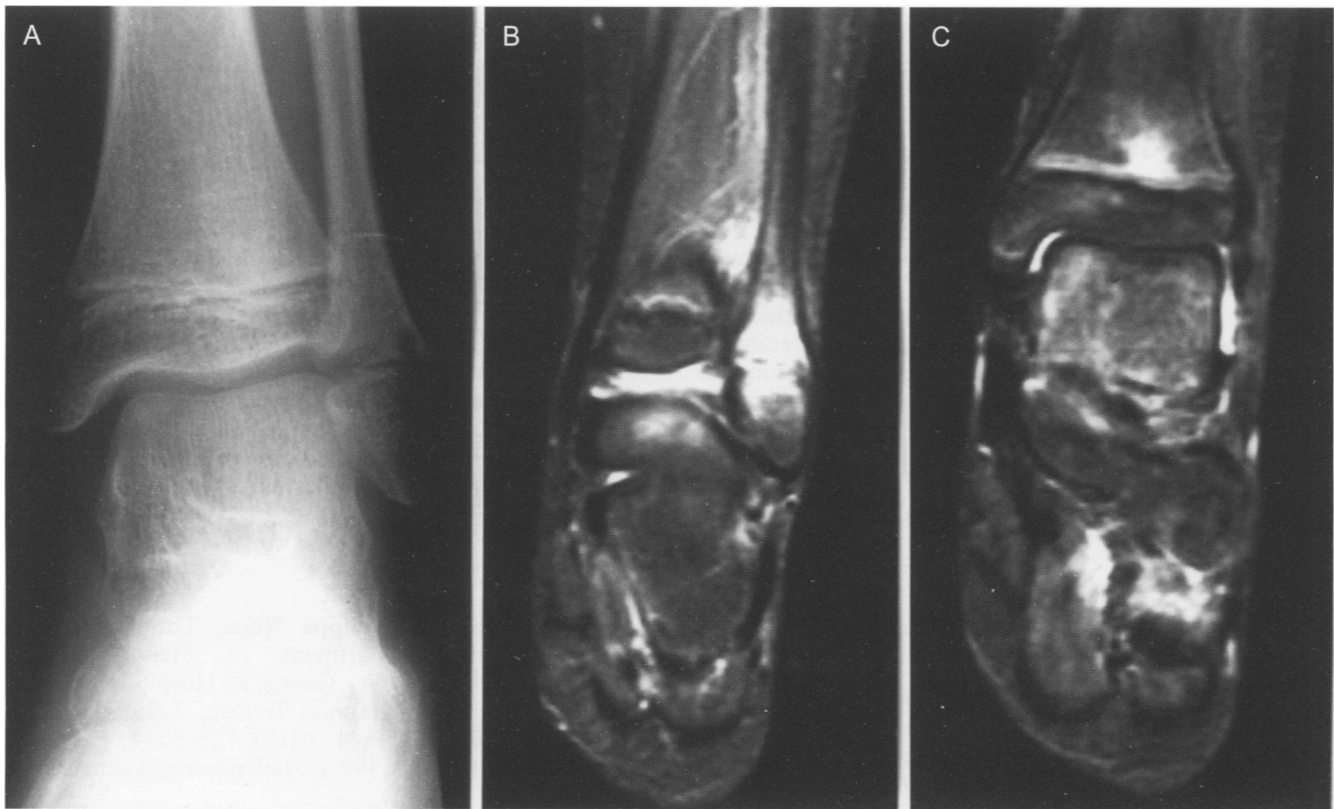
(A) AP radiograph of the left ankle showing a lucency in the fibular metaphysis. (B) Coronal MR STIR sequence of the left fibula showing increased signal in the fibular metaphysis and epiphyseal region adjacent to the growth plate. (C) Coronal MR STIR image of the left tibia demonstrating increased signal focally in the metaphysis.
